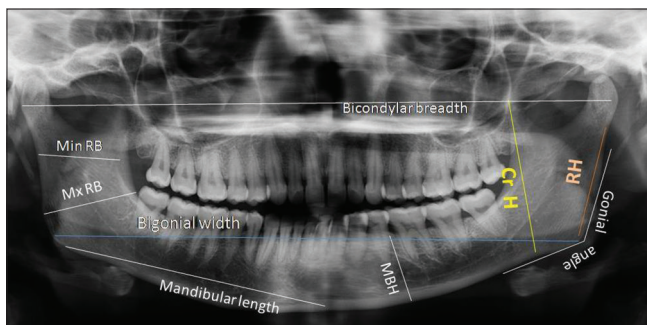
Digital orthopantomograph showing assessed mandibular variables. MinRB = Minimum ramus breadth, MxRB = Maximum ramus breadth, MBH = Mandibular body height, CrH = Coronoid height, RH = Ramus height
